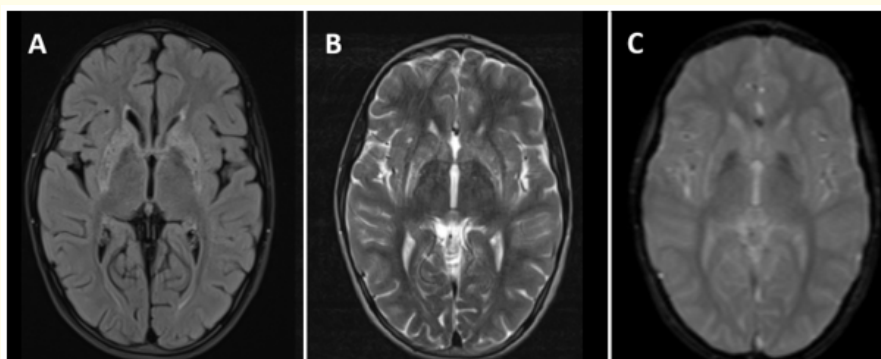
Characteristic brain MRI findings in pediatric Wilson disease.
